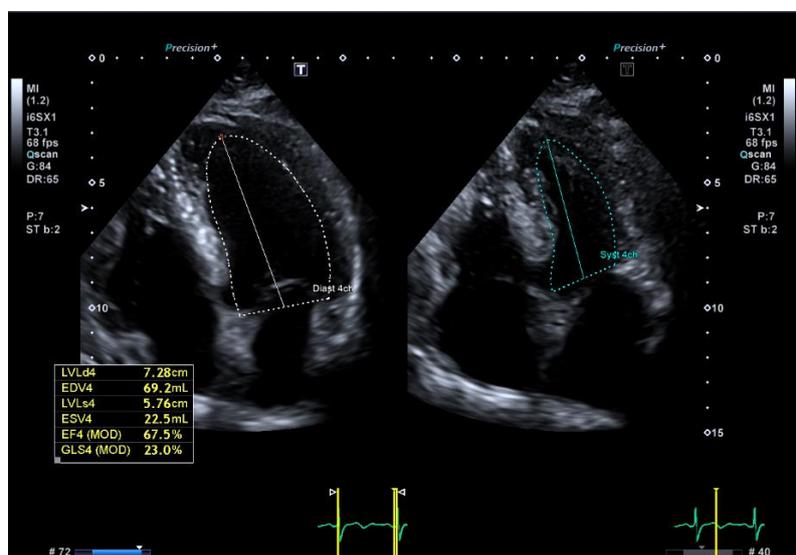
Auto EF in the apical 4 chamber view easily assesses LV function with minimal adjustment required
